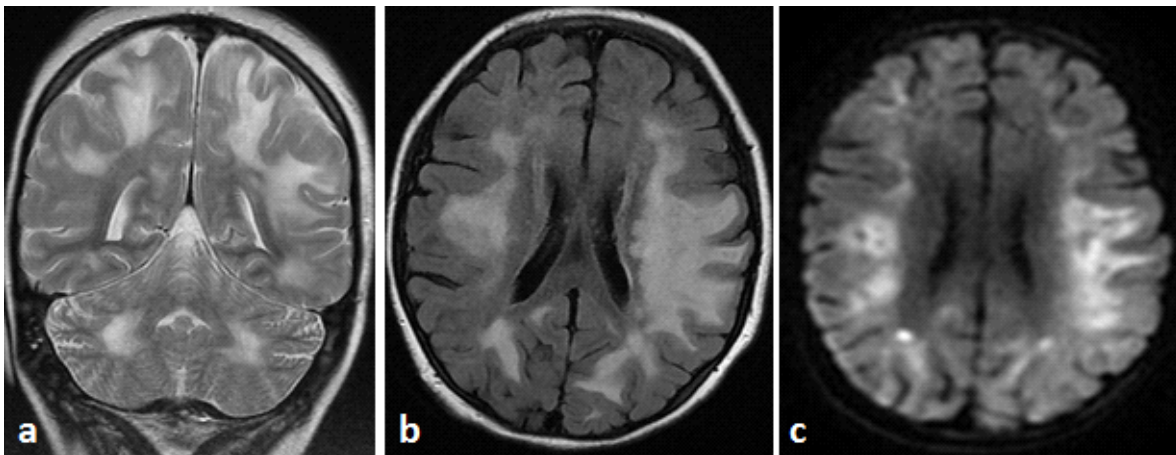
(a): T2-weighted image in coronal section and (b): T2 Flair -weighted image in axial section, Showing extensive hyperintensity in cerebral and cerebellar white matter. (c): Diffusion sequence that objectified a restriction of diffusion in the lesions
